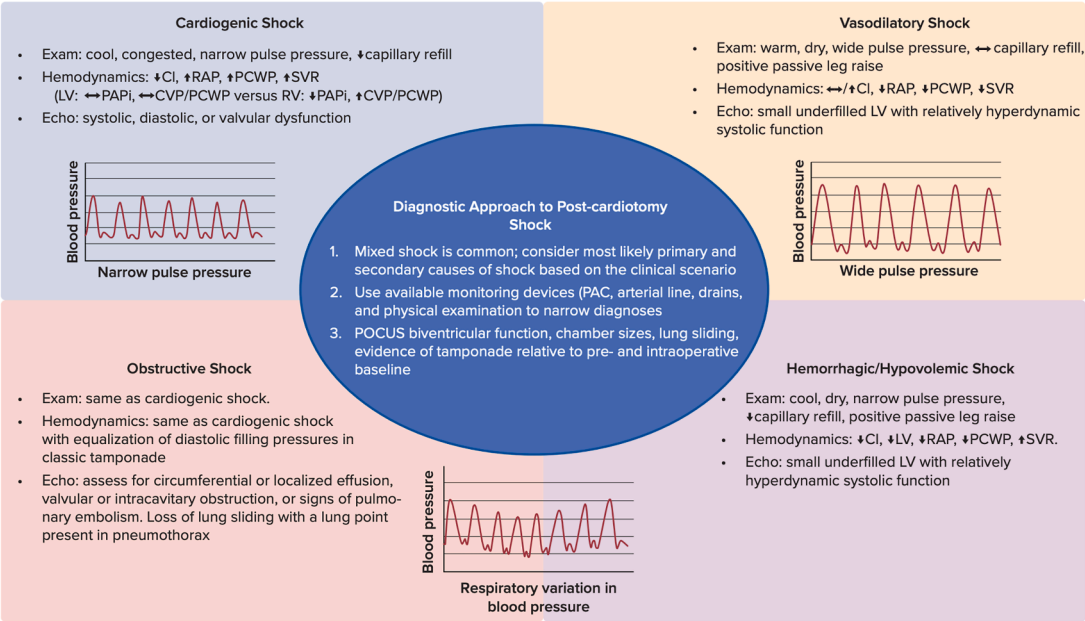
Initial diagnostic approach to PCS. Algorithmic approach to the differential diagnosis of PCS. PAPI, pulmonary artery pulsatility index; POCUS, point-of-care ultrasound; RAP, right atrial pressure. (Previously published materials: *From* Hall EJ, Papolos AI, Miller PE, et al. Management of Post-cardiotomy Shock. *US Cardiol* 2024;18:e11. <https://doi.org/10.15420/usc.2024.16> with permission (requires permission).)
